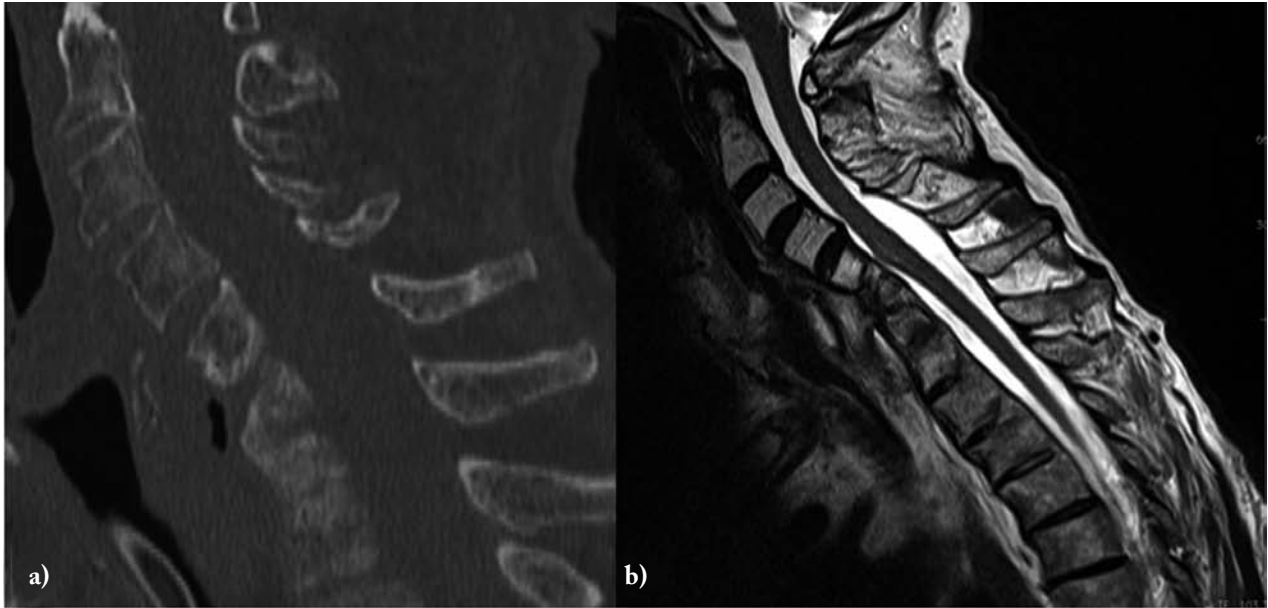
CT (bone algorithm) (a) showing vertebral fusion between C6 and C7 and sagittal T2-weighted MRI (b) showing nearly complete regression of the inflammatory mass
